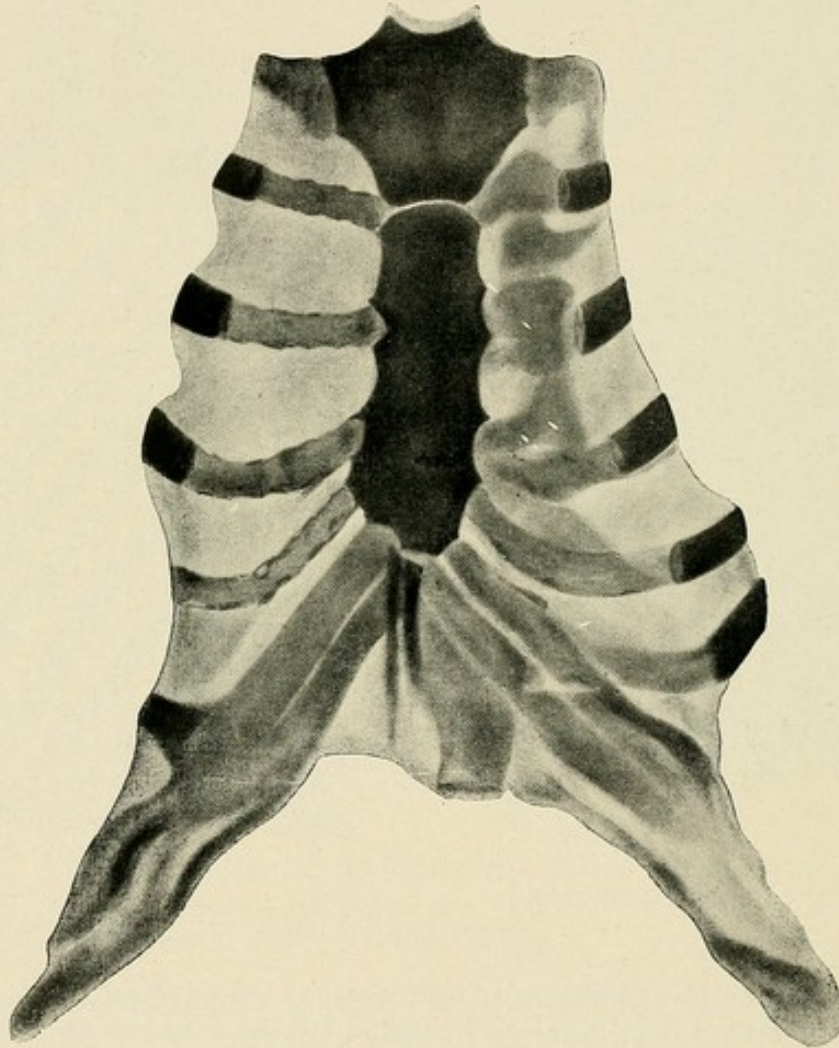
X-ray picture of a thorax 3½ weeks after the operation. Right side operated upon (pseudo-arthrosis). Left side not operated upon, with the characteristic modifications of the cartilage. (Combined picture according to VON DEN VELDEN.)
